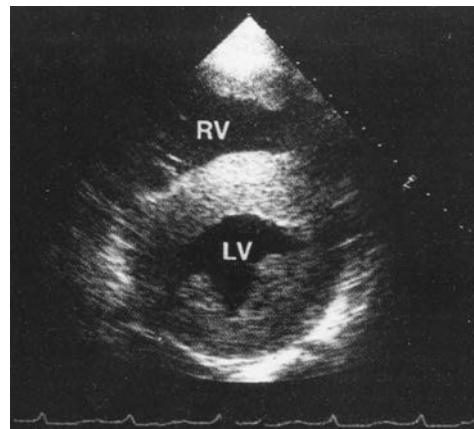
Echocardiographic image of concentric thickening of the wall of the left ventricle (LV) due to amyloid. RV, right ventricle. (From Gertz MA, Kyle RA. Amyloidosis [AL]. In: Wiernik PH, Goldman JM, Dutcher JP, et al., eds. Neoplastic diseases of the blood, 4th ed. New York: Cambridge University Press, 2003. Used with permission.)
